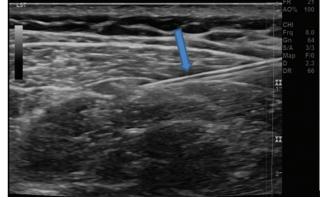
(Case 3)—Ultrasonography image of greater occipital nerve block via 10 mL syringe needle into the perineural sheath for a patient with c/o tension headache.
